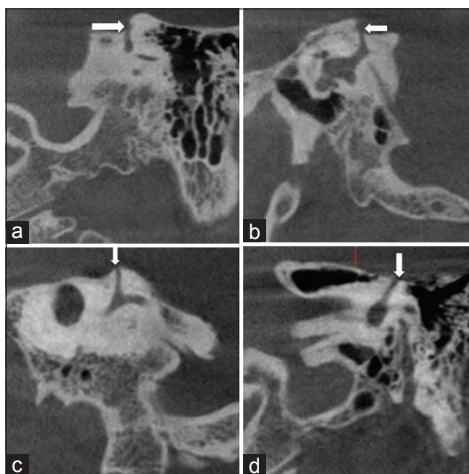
35-year-old male patient with clinical history of vertigo and autophony diagnosed with left superior semicircular canal dehiscence. CBCT of temporal bone (a and d) coronal (b) sagittal (c) oblique sagittal images show a dehiscence of the left superior semicircular canal (white arrow).
